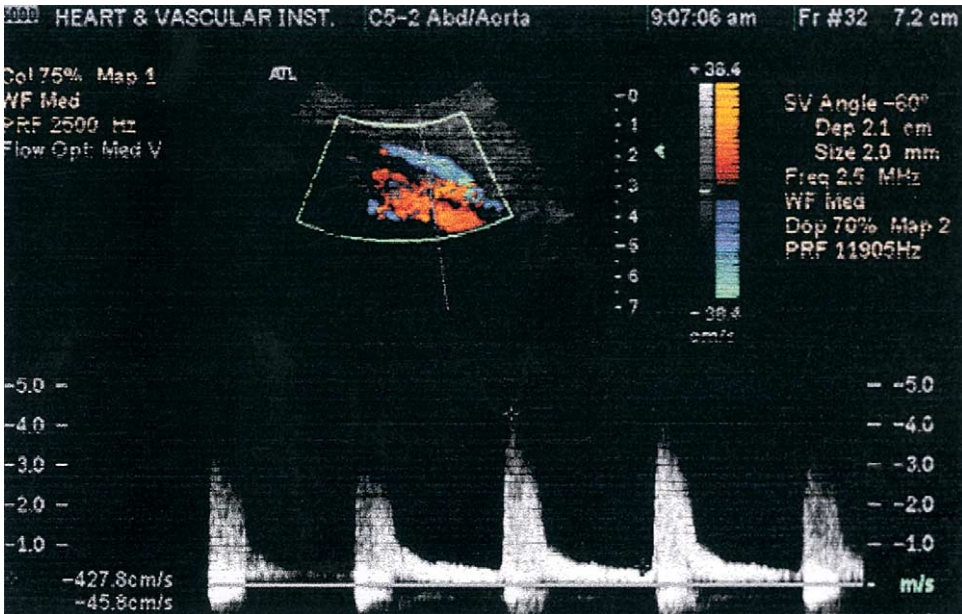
Arterial duplex ultrasound examination demonstrating a 50% to 99% right common iliac artery stenosis. The image is technically adequate and reveals a peak systolic velocity of 427.8 cm/s. The peak systolic velocity of common iliac artery just proximal to this stenosis was 88.2 cm/s.
